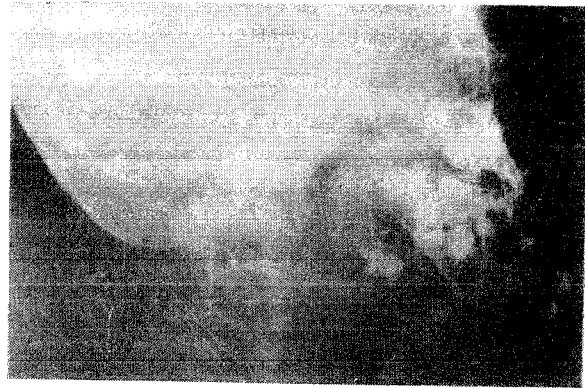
Massive ameloblastoma of the symphyseal region involving both the horizontal rami—Radiographic appearance.
